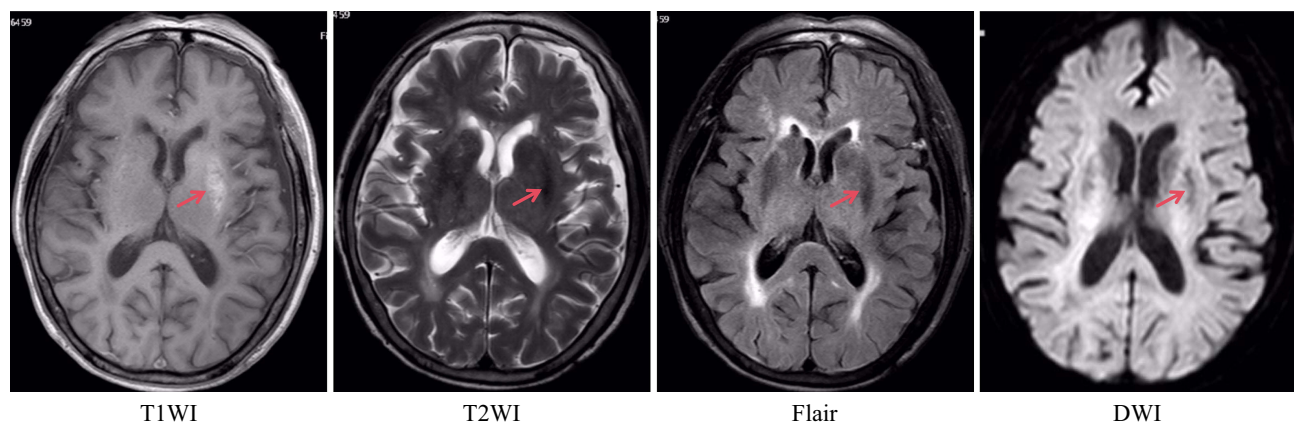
Case 1. An abnormal signal shadow in the left basal ganglia, characterized by a distinct lesion boundary, absence of occupying effects or surrounding tissue edema, and no involvement of the internal capsule. The red arrows point to the lesions. The shadow manifests high signals in T1-weighted images (T1WI), iso-low signals in T2-weighted images (T2WI) and flair sequences, and low signals in diffusion-weighted imaging (DWI).
